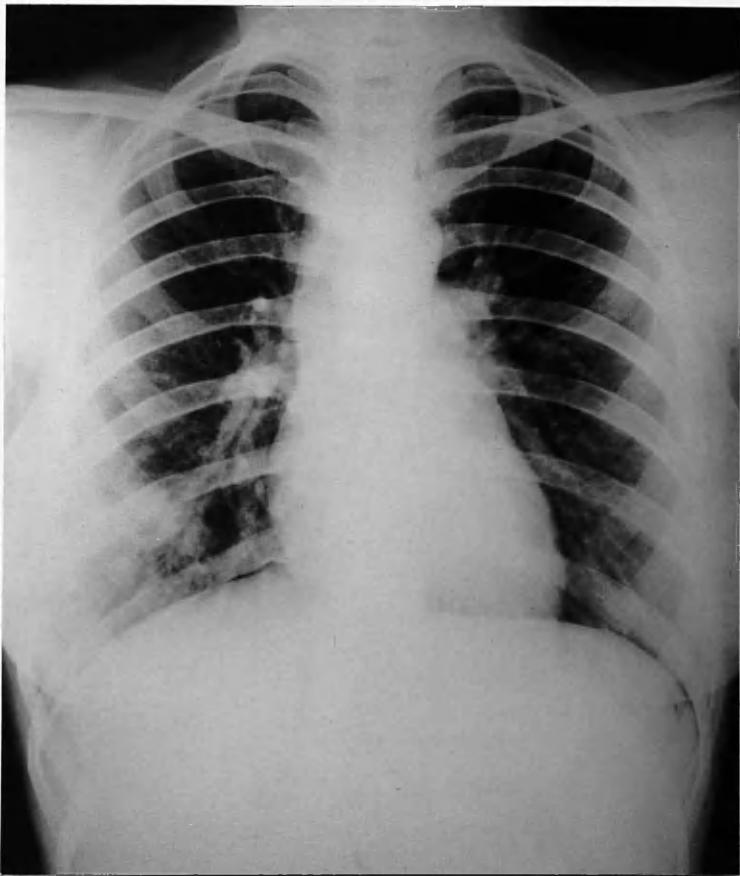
The diagnostic radiograph taken on 15.4.52. There is fairly extensive "soft" shadowing in the right mid- and lower zones with a possible cavity in the fifth intercostal space anteriorly.
